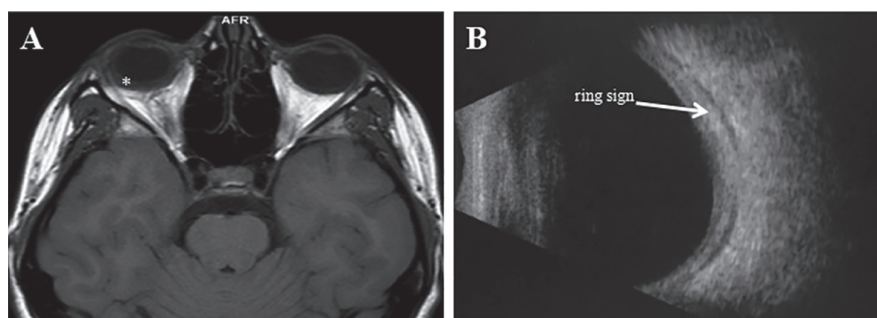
A: Magnetic resonance imaging (MRI) showing a thickened rim of hypointensity on T1 weighted images scan at a choroidal and scleral level in the right eye (*) affected by active posterior scleritis. B: Ocular ultrasonography of the right eye of a patient affected by idiopathic active posterior scleritis: ultrasonography shows a circular acoustically hollow area called the ring sign corresponding to an oedematous Tenon capsule.
